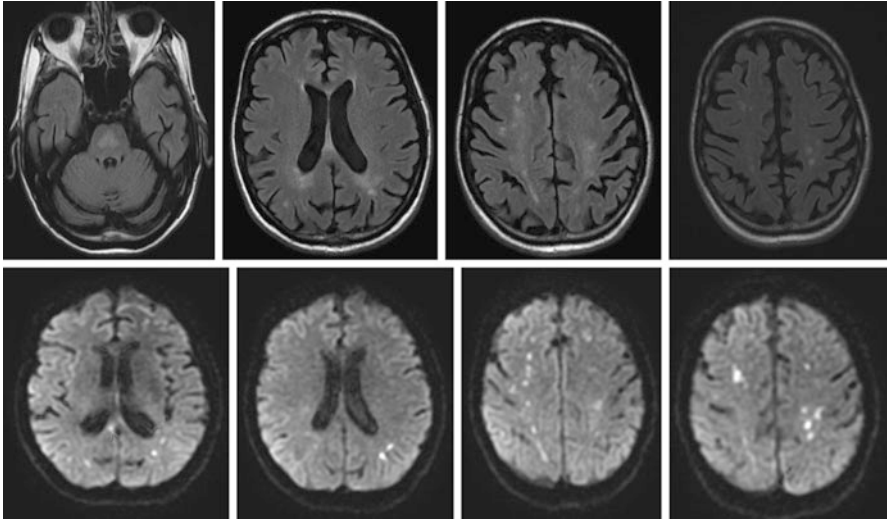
MRI Brain images for Case Example 3. The *top row* shows axial T2 FLAIR images. *Bottom row*: Diffusion weighted imaging (DWI) images which show several areas of diffusion restriction consistent with new strokes appearing as bright spots on imaging
